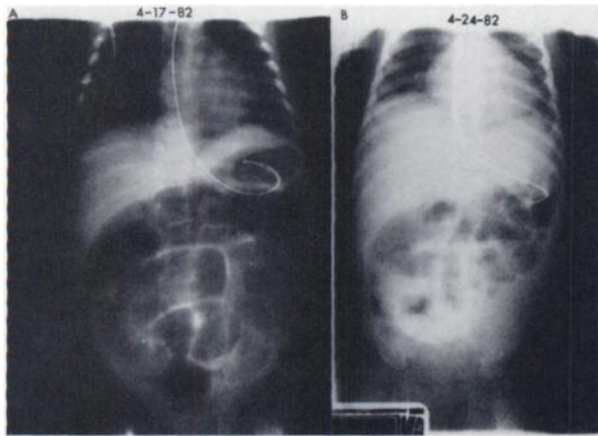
(A). Frontal abdominal radiograph shows distended bowel loops with thickened wall. No free air or air fluid level is noted. NG tube inserted. (B). Repeat study, after treatment with albumin and increased protein, shows significant reduction in bowel distention.
